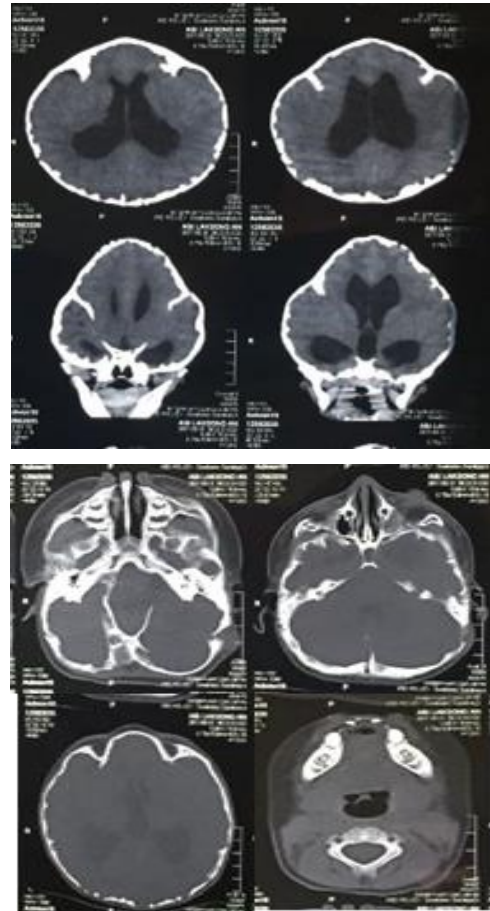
Bone window on computed tomographyscan
